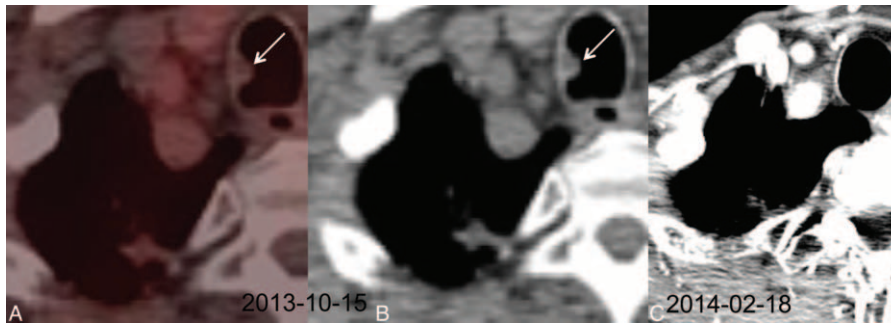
Case 2 (A–C): benign intratracheal condition in a 61-year-old man. ¹⁸F-FDG PET/CT scan showing faint uptake with respect to background activity (SUVmax: 1.2) (A) within a well-defined intratracheal mass-like lesion about 7 mm in size on the noncontrast CT scan of a combined PET/CT (B). The lesion was not observed by 4-months follow-up contrast-enhanced neck CT obtained at the same level (C).
